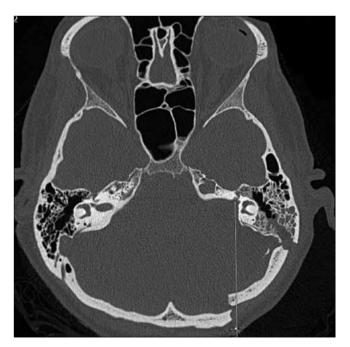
Axial bone window CT scan, the surgical corridor from craniotomy to Fallopius in retrosigmoid RLM, left.
